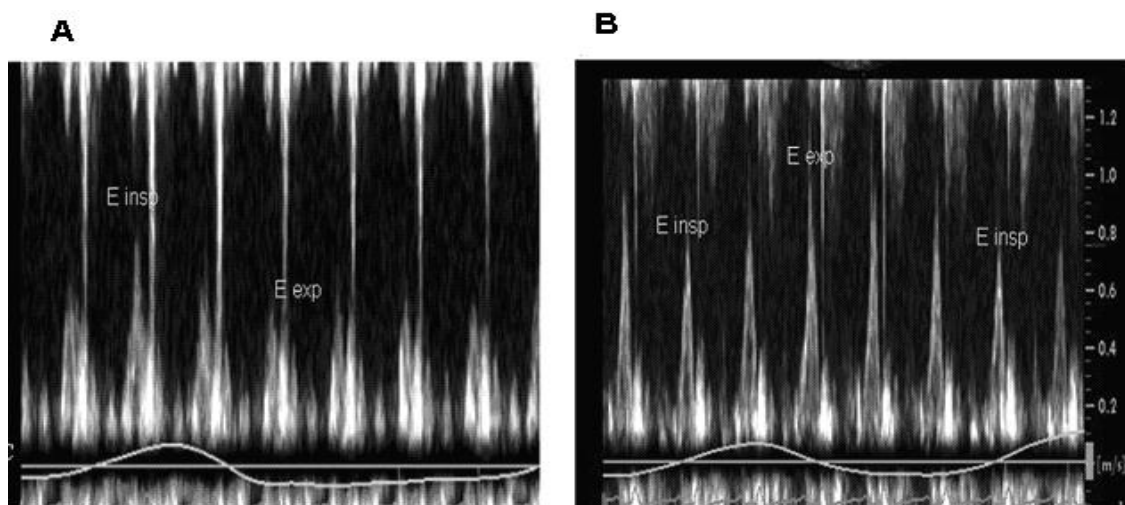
Pulsed wave Doppler respiratory variation in CP. (A) Pulsed wave Doppler echocardiography of the mitral valve with marked (>25%) respiratory changes of early mitral inflow velocity (E). (B) Tricuspid inflow velocity, showing the opposite changes. Tricuspid valve early diastolic velocity, increases with inspiration and decreases with expiration (Verhaert et al., 2010).
